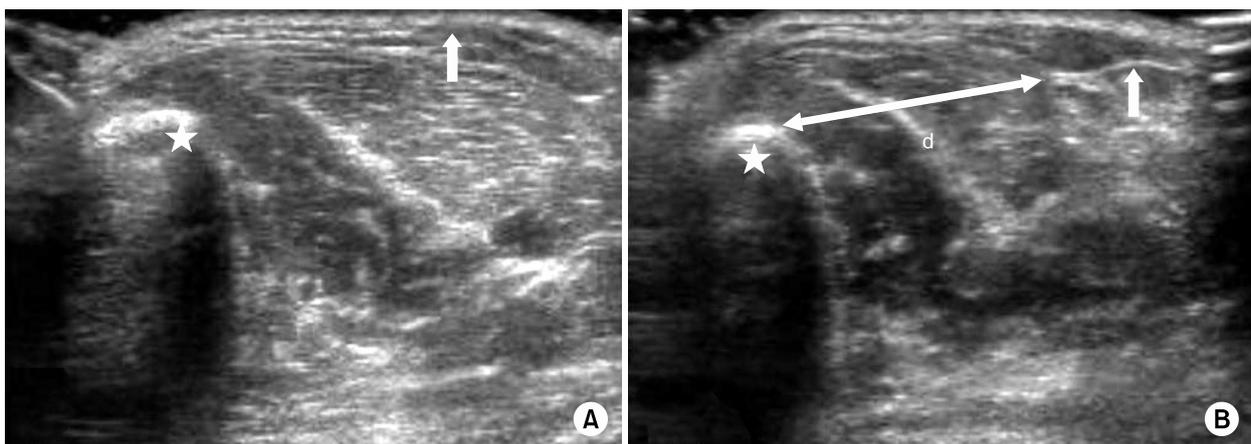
Dynamic transverse ultrasonography of left anterolateral lower leg.
